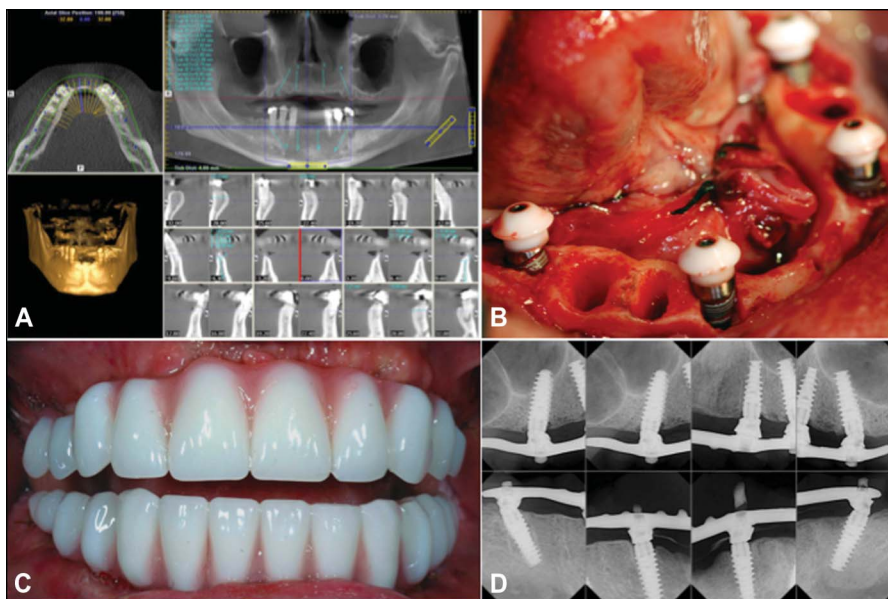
A, Baseline CBCT cross-sections showing the preoperative condition of a 48-year-old patient who was scheduled to undergo implant treatment based on the All-on-4 treatment concept. The green lines show the desired implant locations. B, Intraoperative view of the anterior implants that have been placed straight and the posterior ones that are tilted. C, Clinical view of the fixed provisional restorations that were immediately loaded. D, Radiographic image taken at 36 months postloading. Note the very good maintenance of bone levels around both the straight and tilted implants.
